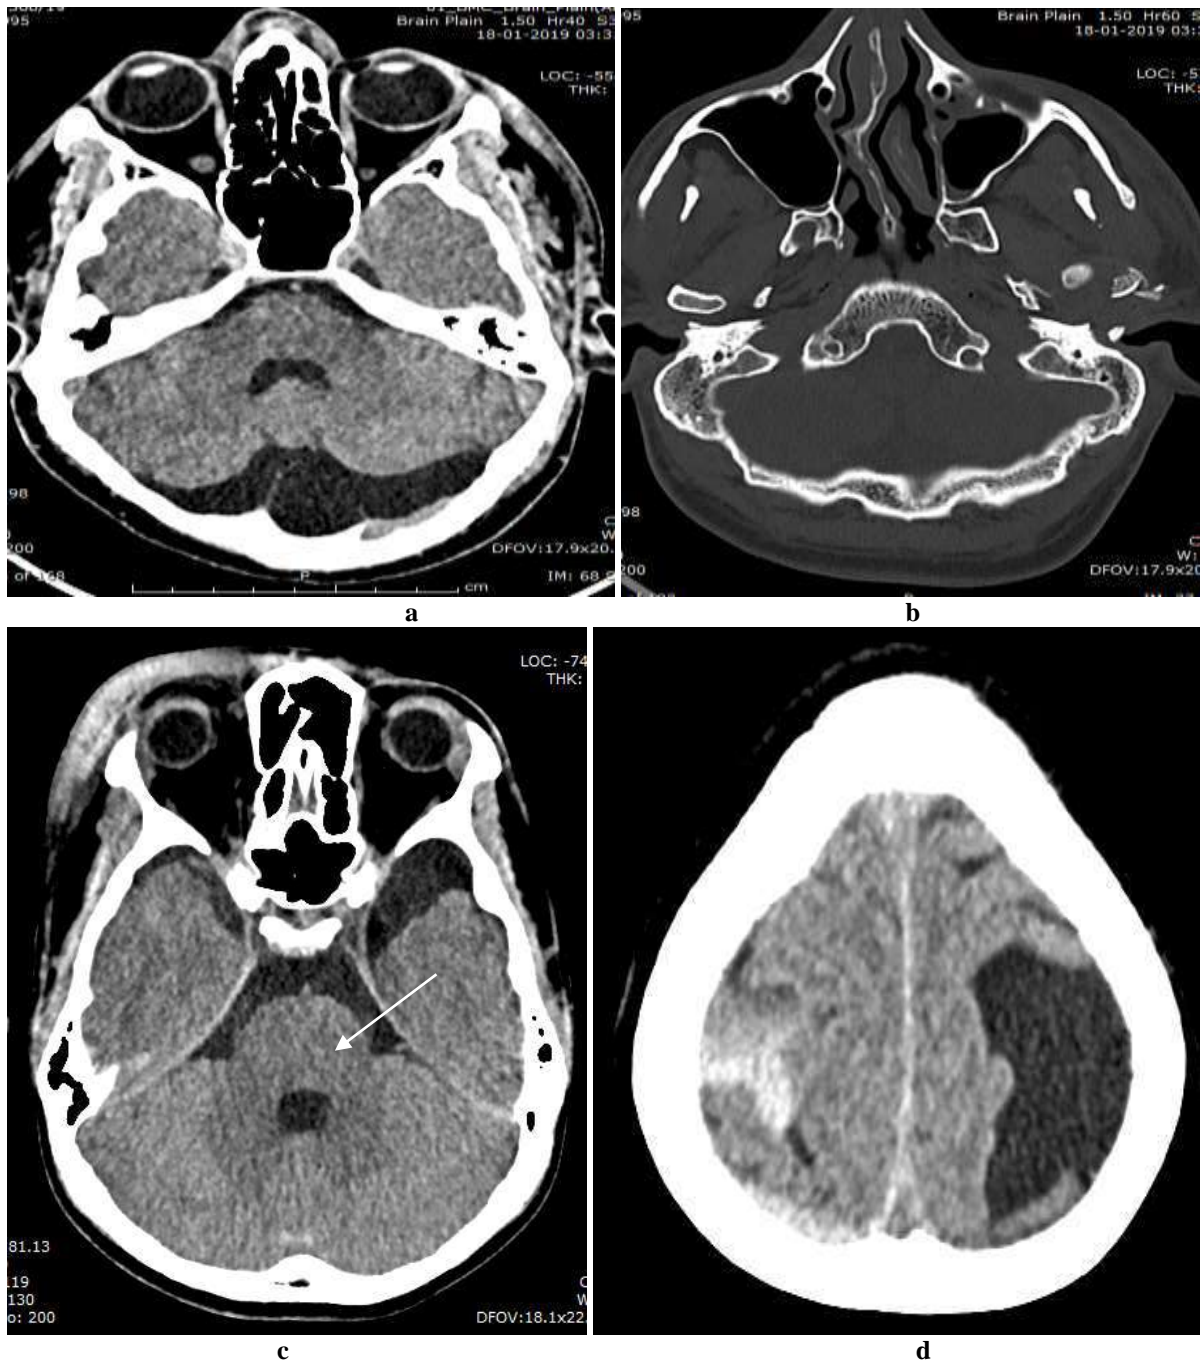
CT brain of a 25 years old male patient with head injury shows retrocerebellar arachnoid cyst (A) and fracture of left condyle of mandible (B). CT brain of 52 years old male patient shows arachnoid cyst in left high parietal convexity with SAH in right parietal region (C). Left anterior temporal arachnoid cyst and right periorbital soft tissue swelling (D)
